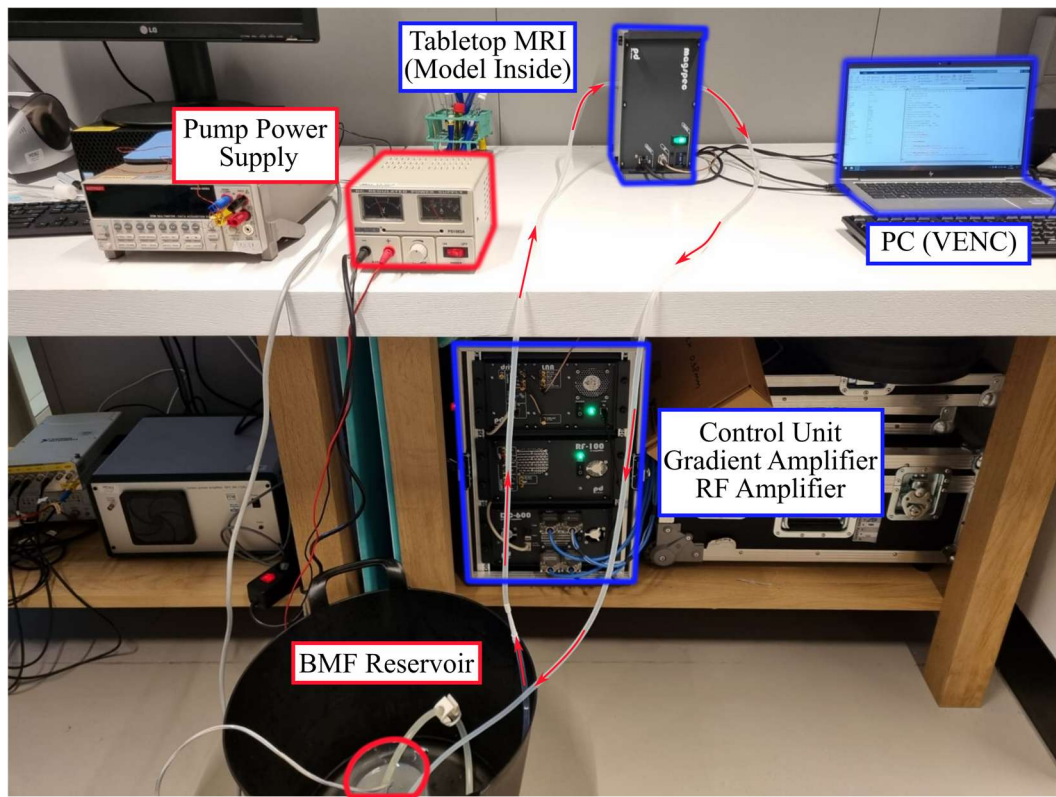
MRI flow apparatus
